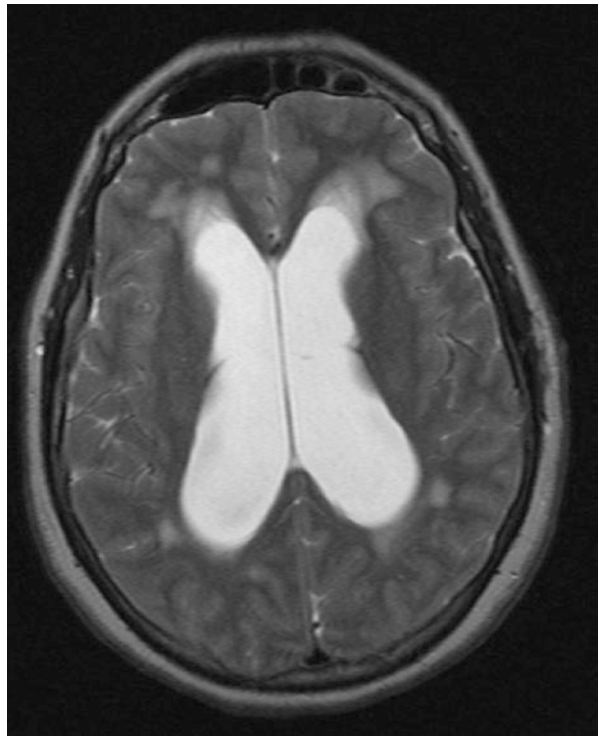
Obstructive hydrocephalus on T2 MRI due to pineal region tumour
